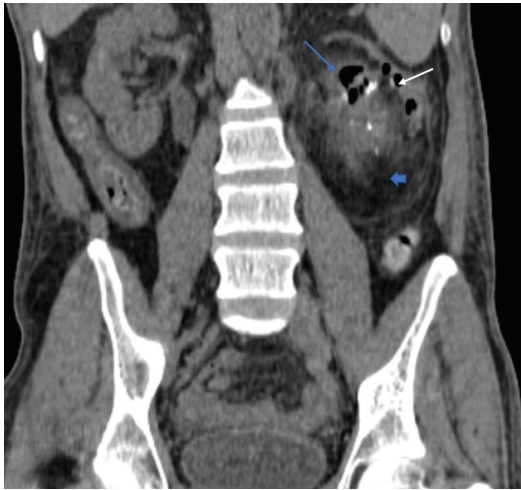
Coronal non contrast CT image shows atrophied left renal parenchyma (white arrow), presence of air (blue arrow) within the left renal pelvicalyceal system and fatty proliferation within left renal sinus and perinephric space (blue blocked arrow).
